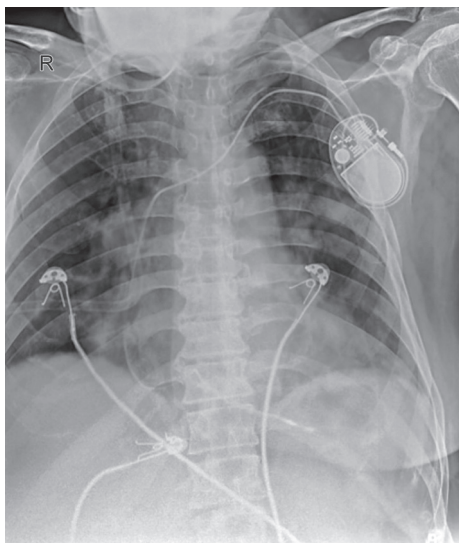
Postoperative X-ray of patient
